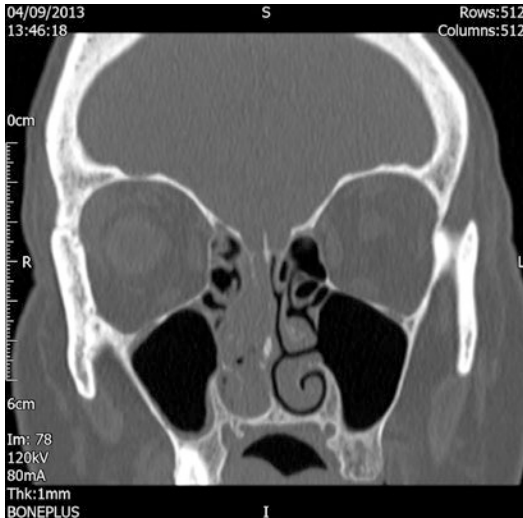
Coronal CT scan of the paranasal sinuses with a soft tissue mass in the right nasal cavity and an intact cribriform plate. The right lamina papyracea and the bony nasal floor appear intact
